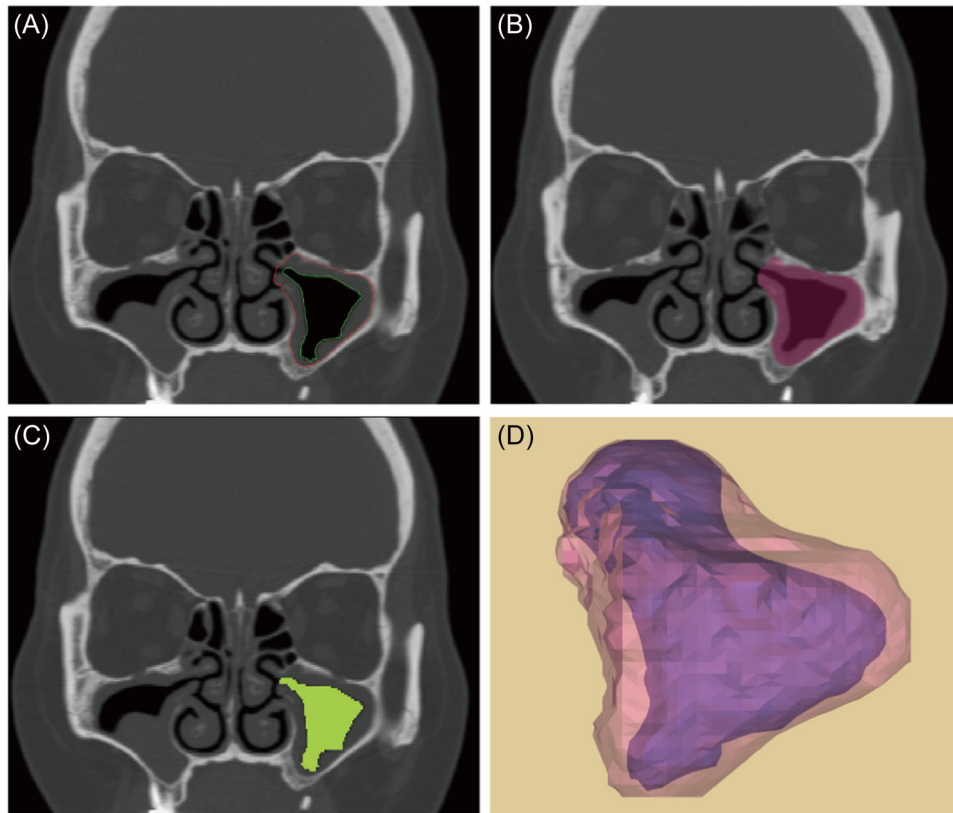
Representative coronal CT images with the manual outlines and maxillary sinus 3D model. (A) Coronal CT images of representative sinuses with the original maxillary sinus volume outlined with red lines and the maxillary remaining cavity volume indicated by green lines. (B) Original maxillary sinus volume constructed from single layer CT image contours. (C) Remaining maxillary sinus cavity volume constructed from single layer CT image contours. (D) 3D model of representative maxillary sinus constructed from multilayered CT images, purple indicates remaining cavity and red indicates original sinus volume. 3D, three dimensional; CT, computed tomography.
